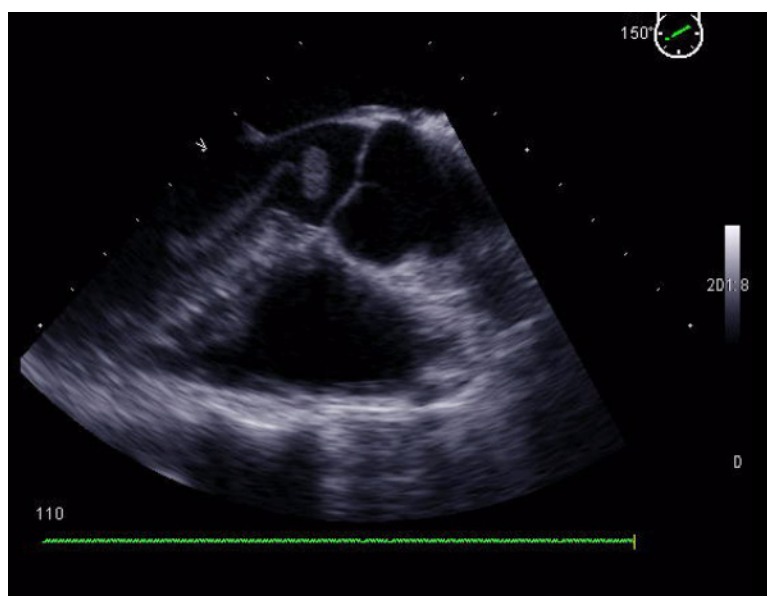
Trans-esophageal echocardiography in the long axis view showing a large, highly mobile thrombus resembling a fist, punching the aortic valves.
